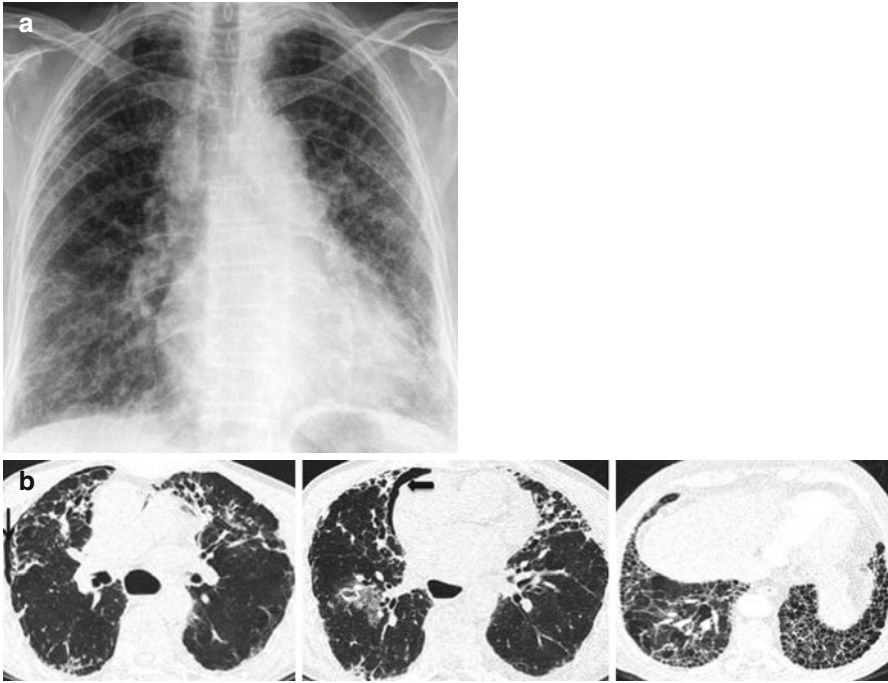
(a) Chest radiograph in a 65 year old with widespread bilateral interstitial fibrosis. (b) High resolution CT thorax in the same patient during an acute admission better demonstrates the subpleural reticulation, traction bronchiectasis and basal honeycombing characteristic of usual interstitial pneumonitis complicated by small right lateral (*thin black arrow*) and anteromedial (*thick black arrow*) pneumothoraces
